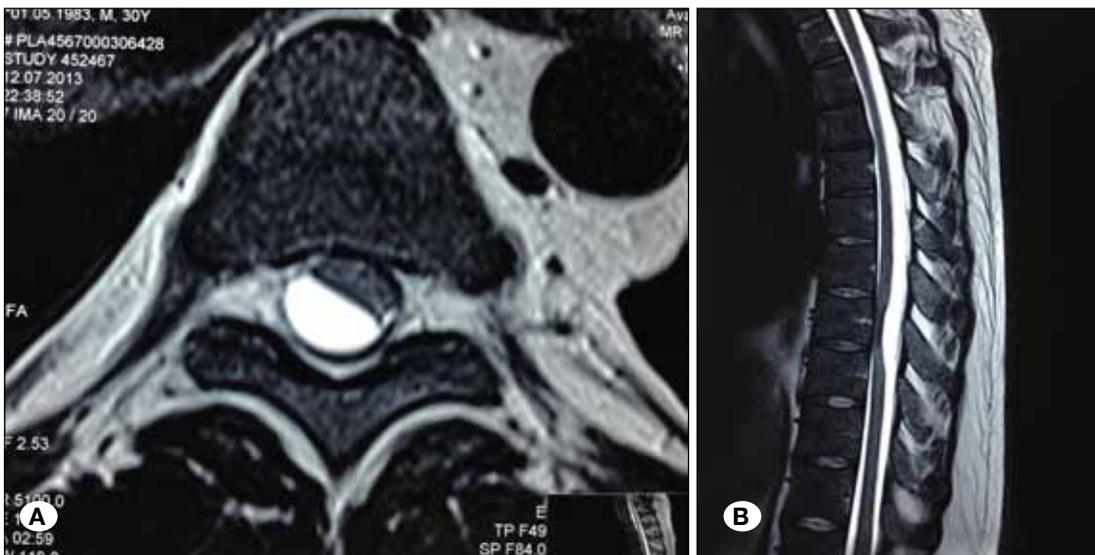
Axial (A) and sagittal (B) T2-weighted MRI scans show a cystic lesion invading the spinal canal at the posterior of spinal cord.
